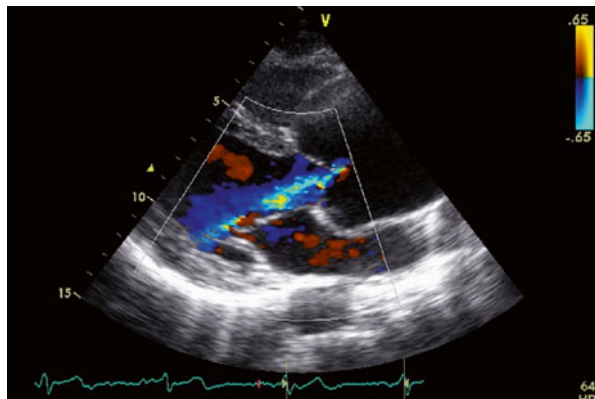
Parasternal long axis view with central jet of aortic regurgitation
